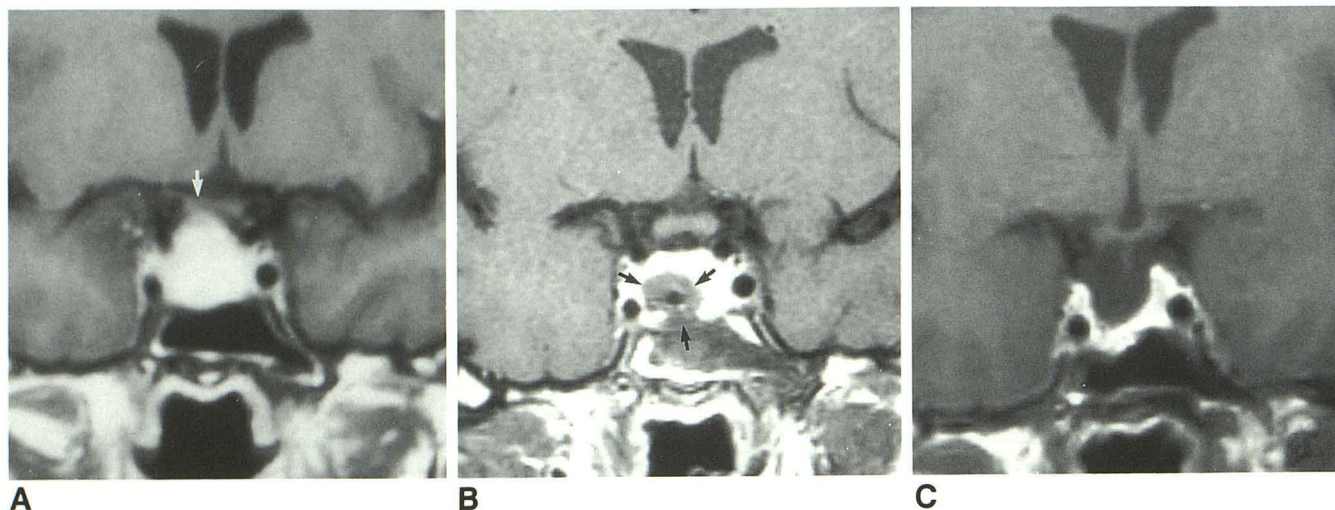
A, Preoperative enhanced coronal T1-weighted image. A macroadenoma slightly elevates the optic chiasm on the right (arrow).
